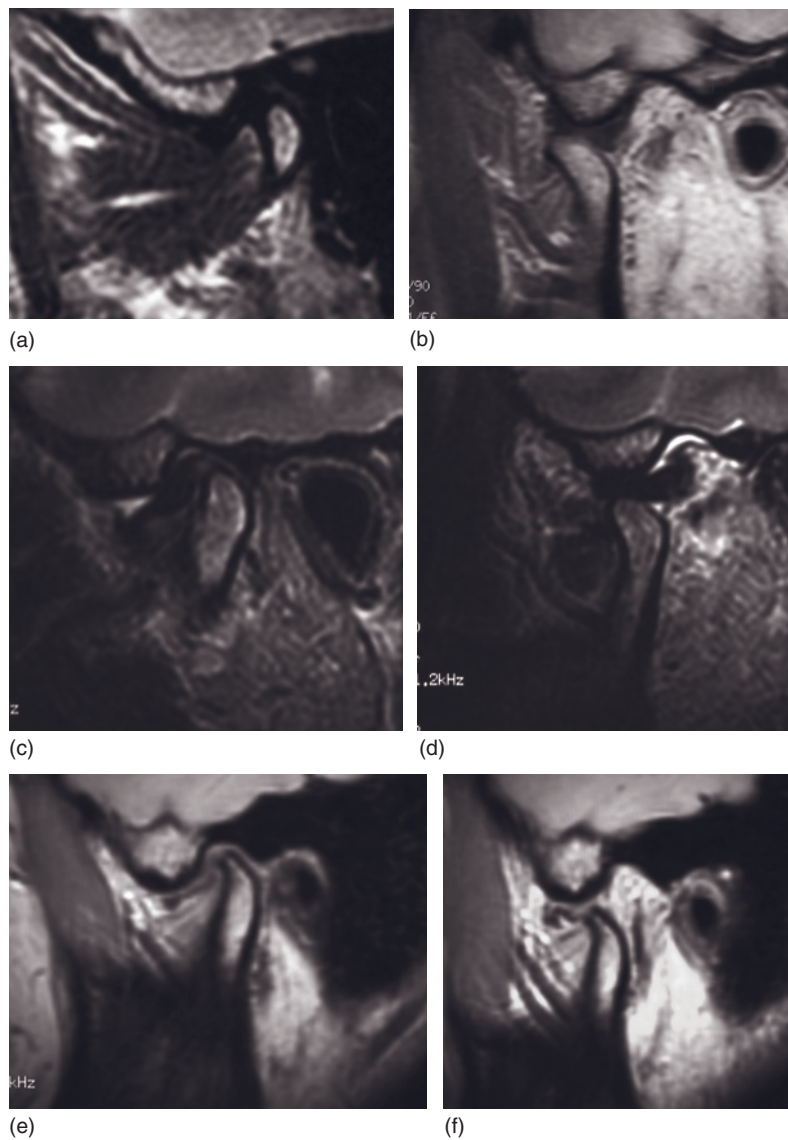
Magnetic resonance imaging scans of the temporomandibular joint in the closed and open positions, showing normal anatomy and disease. See text for details.
